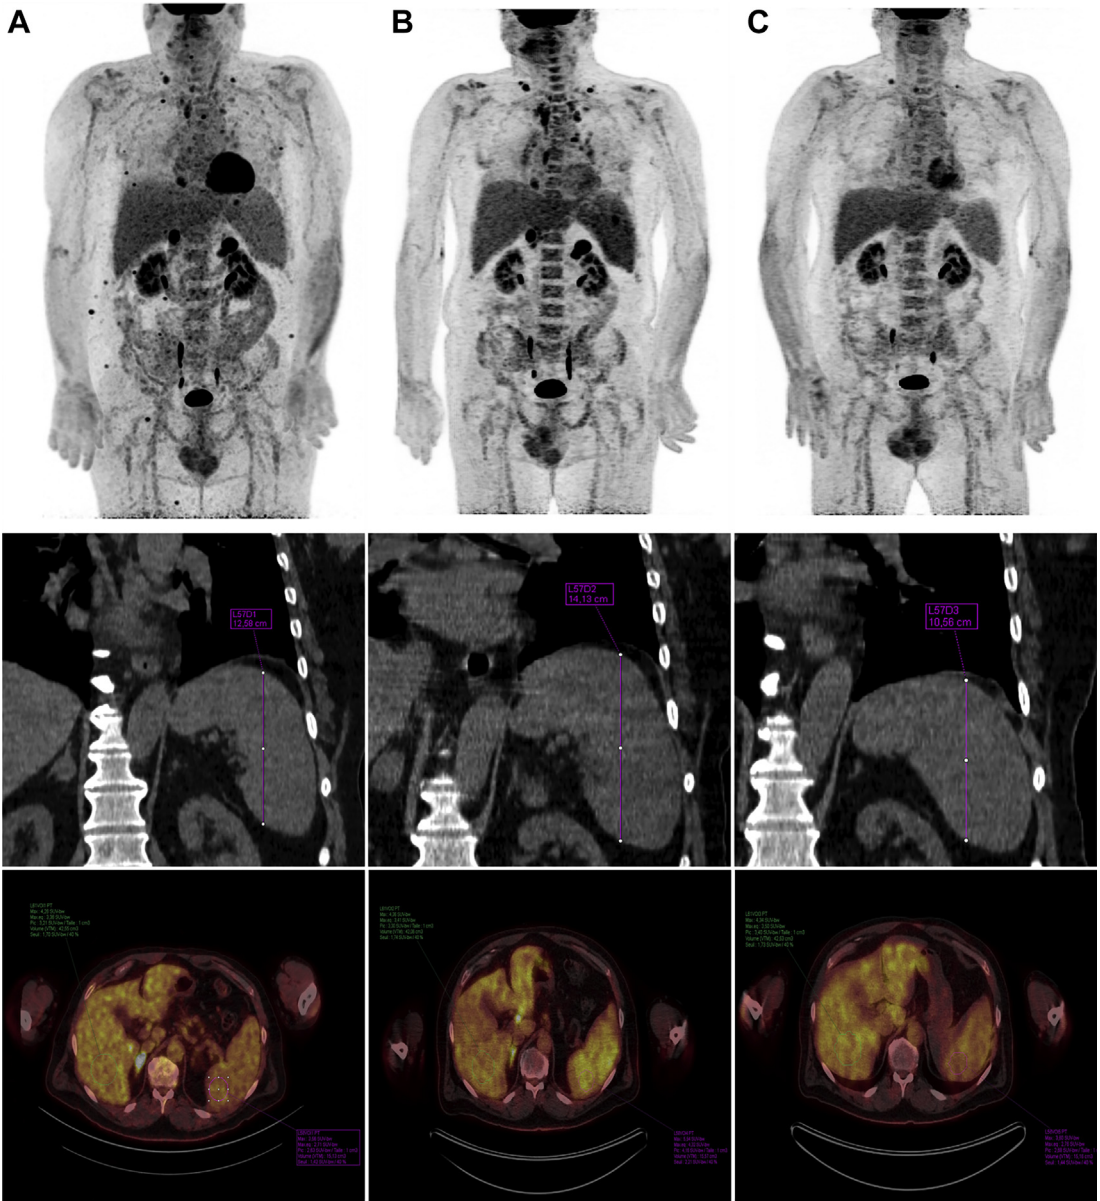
How to seek immune activation on FDG PET. Serial ^{18}F FDG PET/CT in different phases of the disease in a 61-year-old man affected by a melanoma of the left forearm with subcutaneous lymph nodes and bilateral adrenal glands involvement. (A) Baseline PET before introduction of immunotherapy and (B) after 2 courses of nivolumab, showing diffuse osteomedullary hypermetabolism, an inversion of the spleen-to-liver ratio associated with an increase in the spleen dimensions in line with a lymphocyte activation. This pattern precedes (C), an excellent partial metabolic response that is observed after 5 courses of nivolumab in all lesions.
